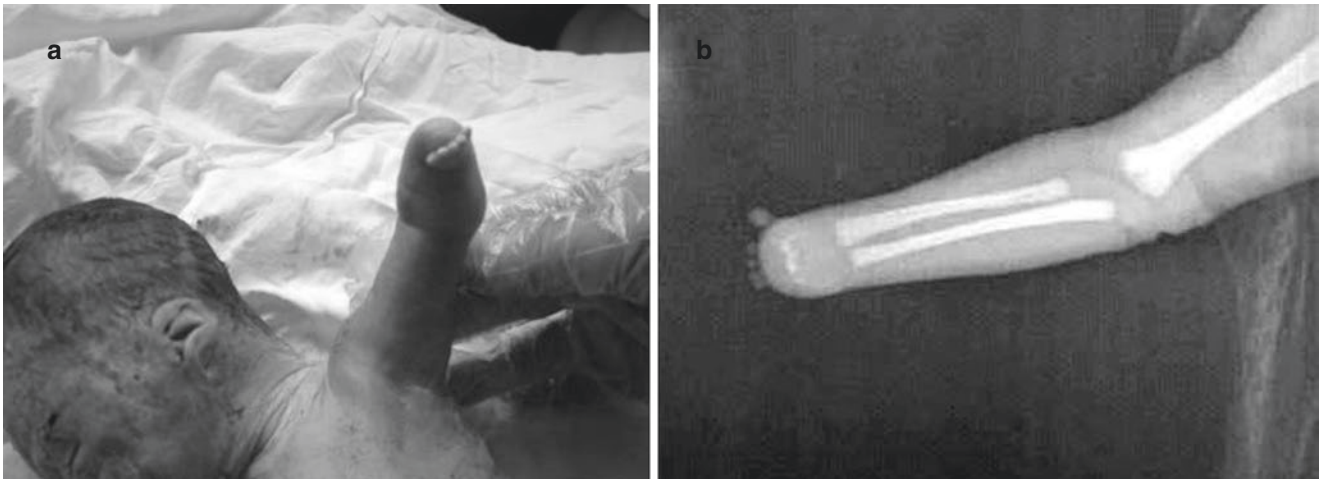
Fetal forearm absence with hand deformity after induction labor. (a). Picture after induction labor. (b). X-rays of the same induced fetus
